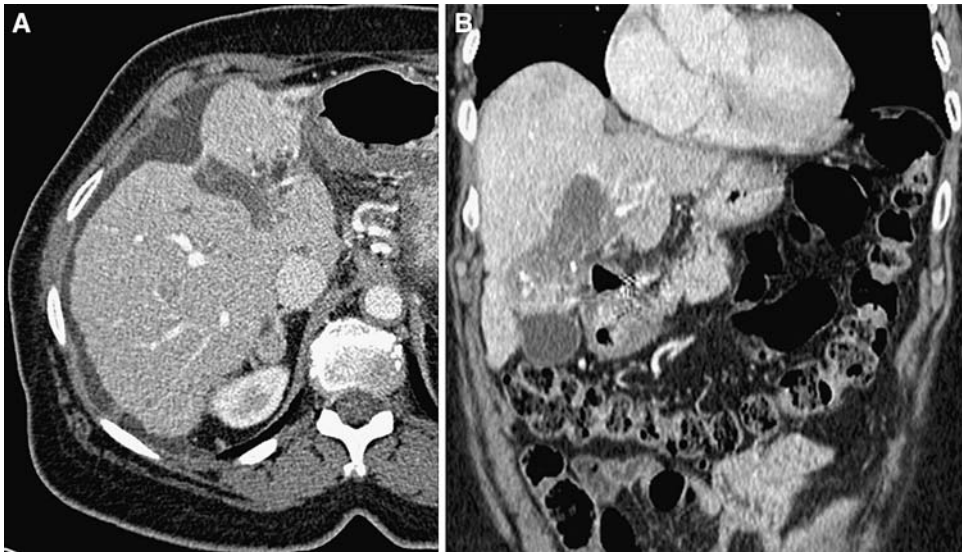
(A) Post-treatment contrast-enhanced CT in the arterial phase demonstrates a fluid collection representing a small biloma. (B) In the same patient as Fig. 15A, the coronal view also confirms the presence of the biloma.
